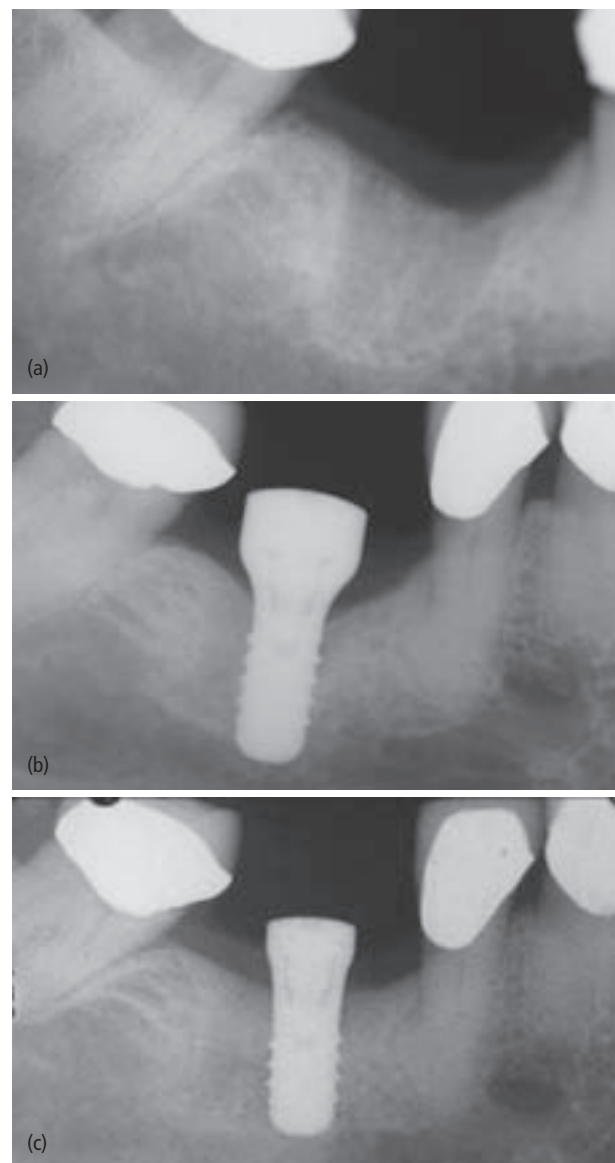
Inferior alveolar nerve at apex of the extraction site. (a) Initial periapical radiograph of extraction site (tooth 30). (b) Implant in inferior alveolar canal (Panorex, site 30 is enlarged). (c) Implant placed at site 30 coronal to the inferior alveolar canal.
